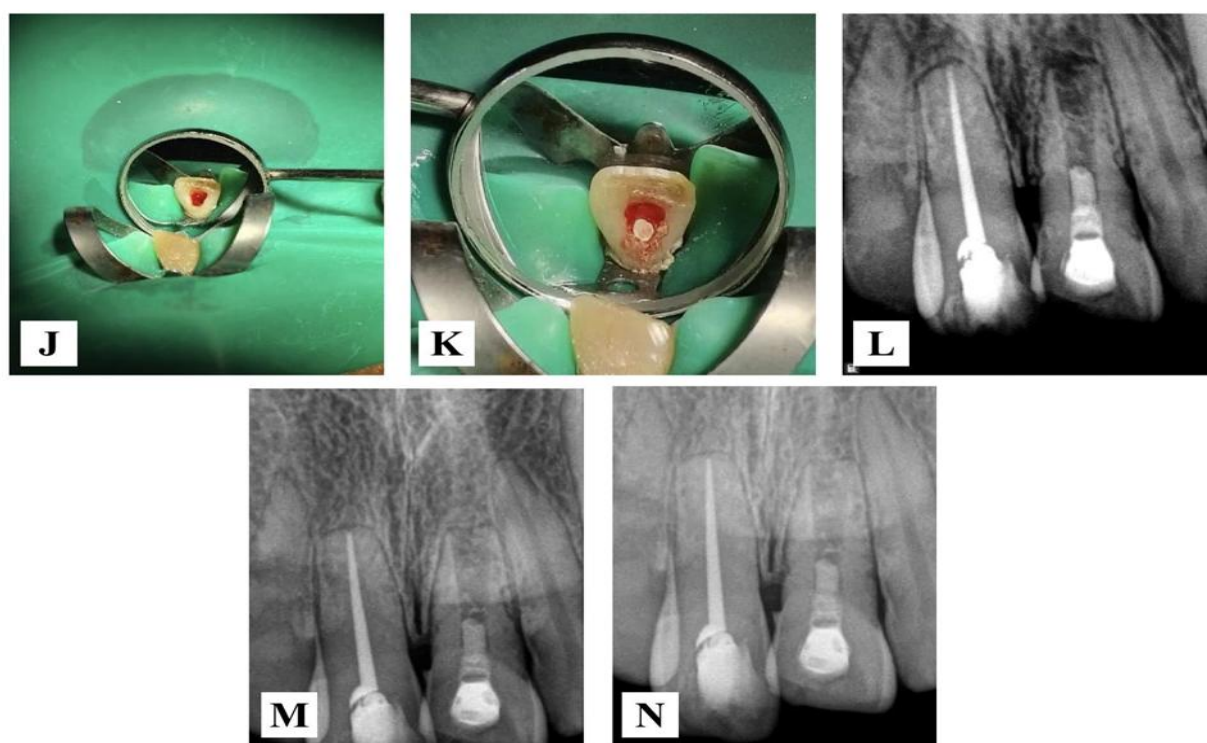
Placement of preset MTA plug and follow-up outcomes. (J) Induction of intracanal bleeding to create a scaffold for regeneration. (K) Clinical placement of the preset MTA plug over the blood clot scaffold. (L) Immediate postoperative radiograph after final restoration. (M) Six-month follow-up radiograph showing reduction in periapical radiolucency. (N) One-year follow-up radiograph showing continued healing and increased root thickness
